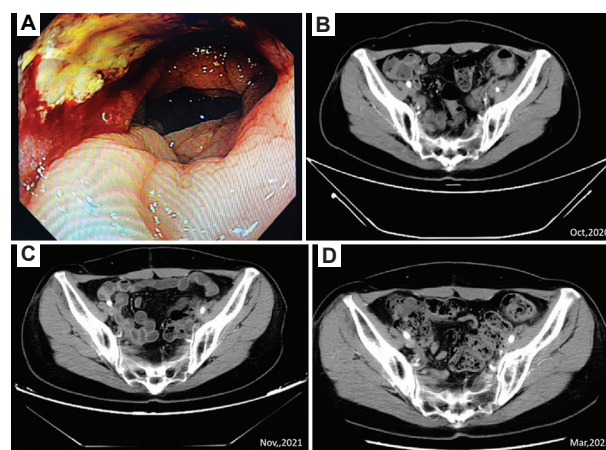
A case of colorectal cancer with distinct clinicopathological features. (A) Image from the colonoscopy. (B) Computed tomography scans on the first examination, (C) second follow-up, and (D) the past follow-up.
